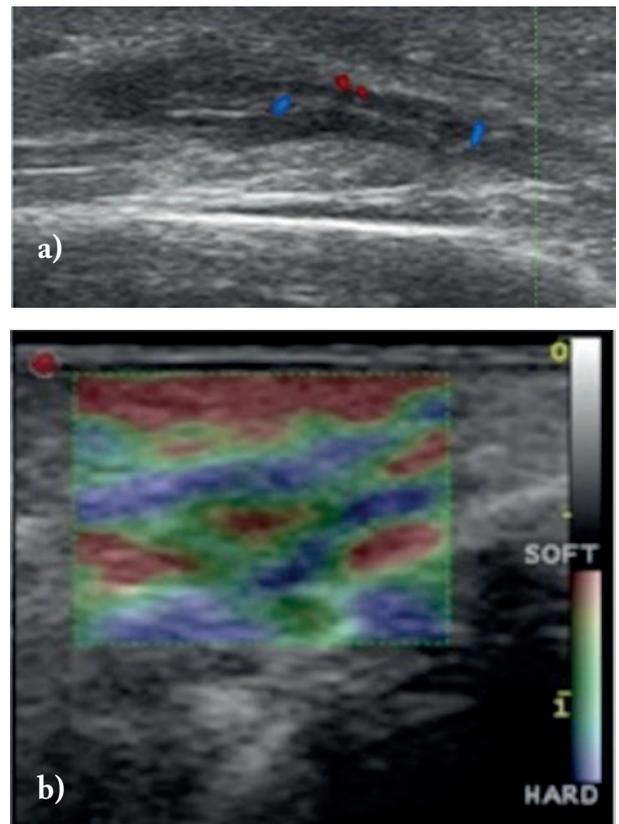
(a) Color-Doppler US (longitudinal view): few vascular signals inside and around the radial nerve. (b) US-elastography (axial view): the soft tissue nodule showed elasticity in the whole area with a contextual small mixed red area inside
